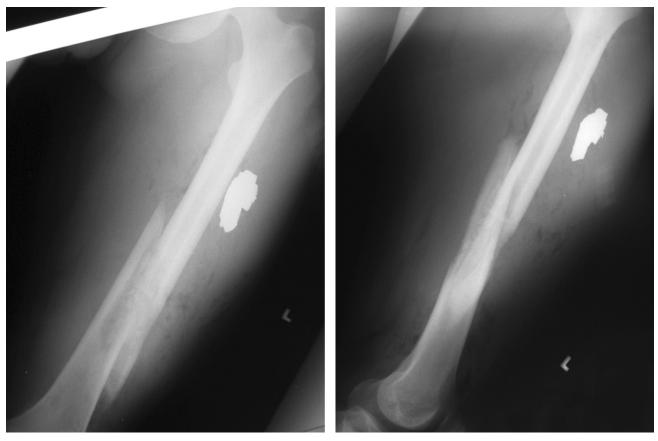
PA (Left) and lateral (Right) radiographs show midfemoral fracture and metallic fragment that caused the injury. There is extensive soft-tissue air.
